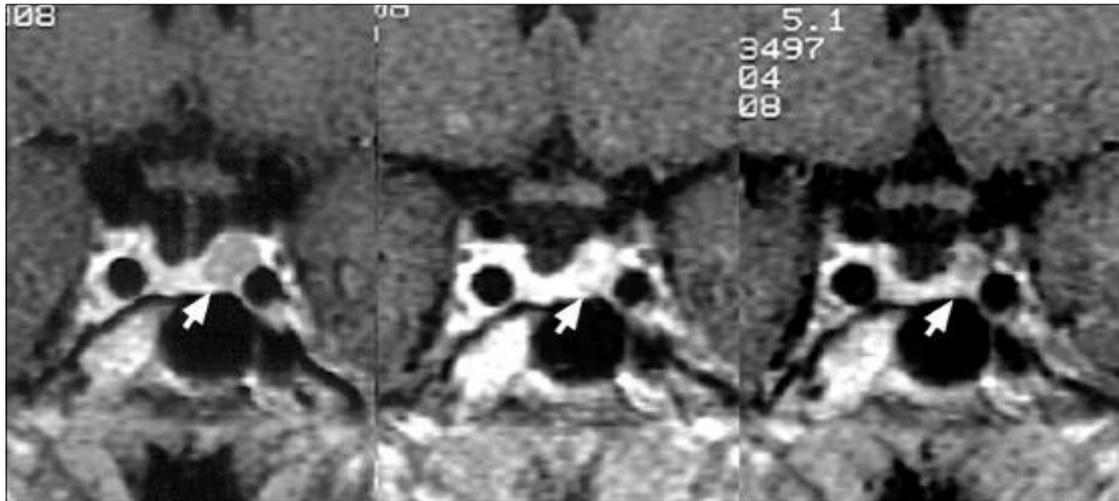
Sellar dynamic MR images demonstrating the process of pituitary adenoma following Gamma Knife radiosurgery (GKS). Left: Initial MRI showing pituitary adenoma (arrow). Center: MRI obtained 13 months after GKS. Right: MRI obtained 30 months after GKS. Note the marked tumor shrinkage. This patient is a 47-year-old woman who underwent GKS (Maximum dose: 70 Gy, margin: 50%). Her initial PRL level was 337 ng/ml. Hormonal response was observed 3.2 months after GKS. Subsequently, her PRL level dropped to the normal range 42.5 months after GKS.
